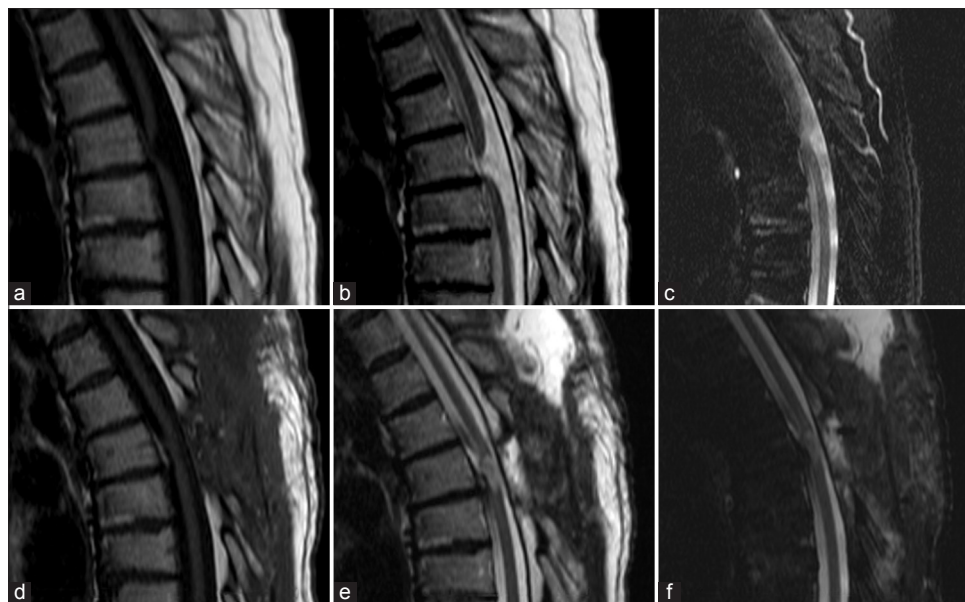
Magnetic resonance of the dorsal spine [sagittal acquisition – (a and d) T1-weighted images; (b and e) T2-weighted images; (c and f) SPIR (Selective partial inversion recover) T2-weighted images] demonstrating the spinal cord herniation (a-c) and the radiological result following surgical treatment (d-f)
